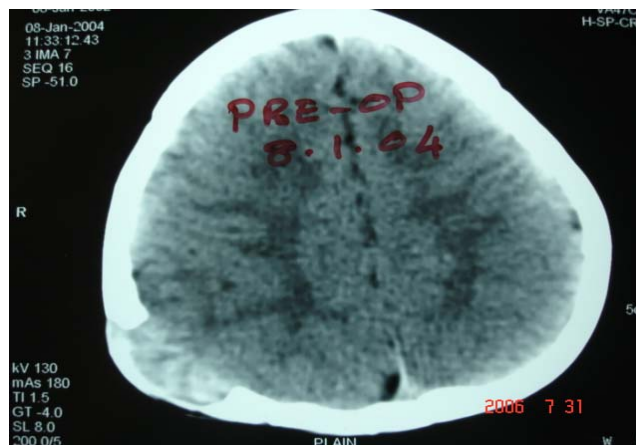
Preoperative CT scan showing Growing Skull Fracture (GSF): bony-defect in this case was larger than the dural defect. Large lepto-meningeal cyst, cortical tissue entrapment
